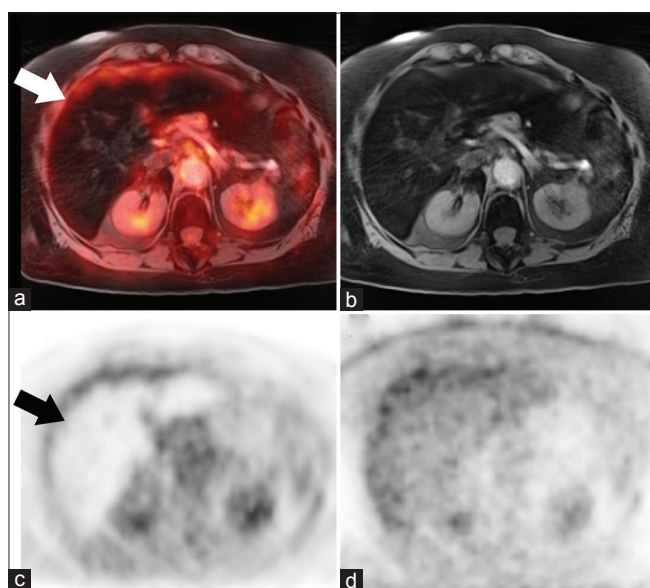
Positron emission tomography-magnetic resonance imaging fusion with T1 radial volumetric interpolated breath-hold examination with fat suppression acquired in the axial plane showed severely decreased radiotracer activity throughout the liver parenchyma (white arrow) (a). Corresponding axial T1 radial volumetric interpolated breath-hold examination with fat suppression image (b) revealed generalized decreased magnetic resonance signal in the liver. Axial positron emission tomography attenuation corrected image (c) showed severe decreased liver uptake (black arrow) which was not present on the nonattenuation corrected images (d)
